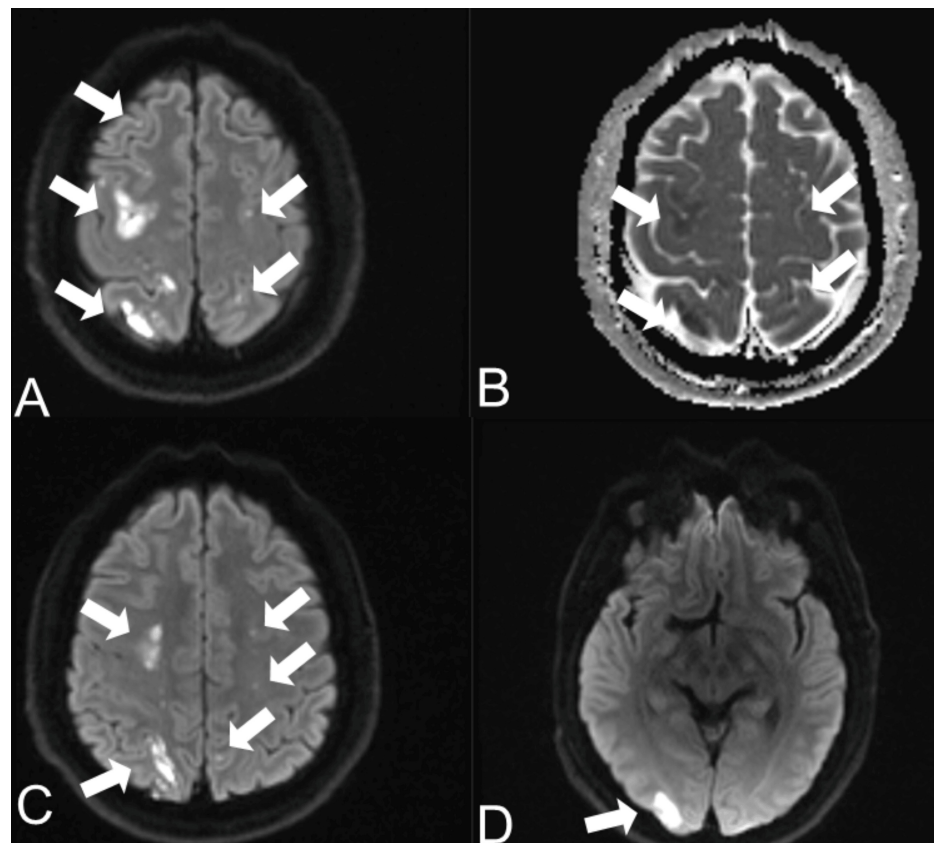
Brain MRI on hospital day 2 demonstrating multiterritorial ischemic infarcts
